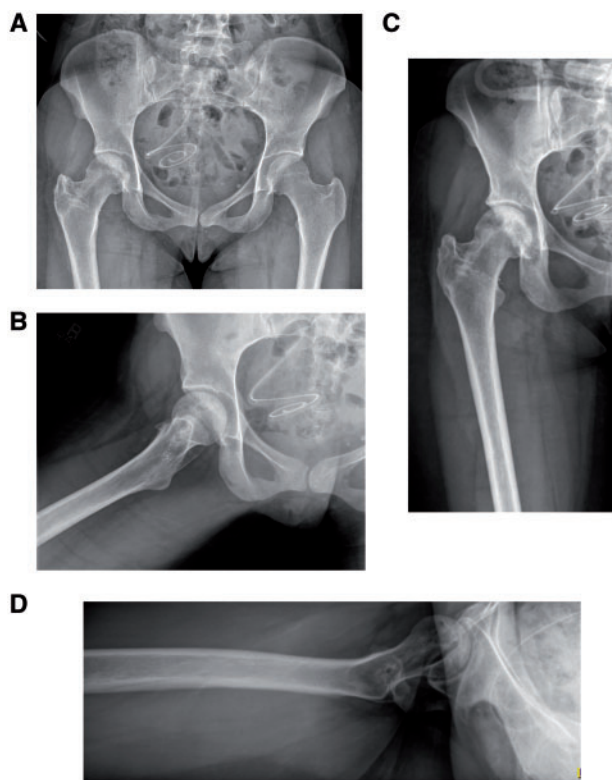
Postoperative imaging. Anteroposterior view of the pelvis (A), anteroposterior X-ray of the right hip (B) as well as frog-leg (C) and cross-table (D) lateral X-rays of the right hip at 5 years of follow-up. She continues to be pain-free with her right hip and is satisfied with the procedure. Note preservation of her femoral head as a sphere and maintenance of her joint space without degenerative changes.
